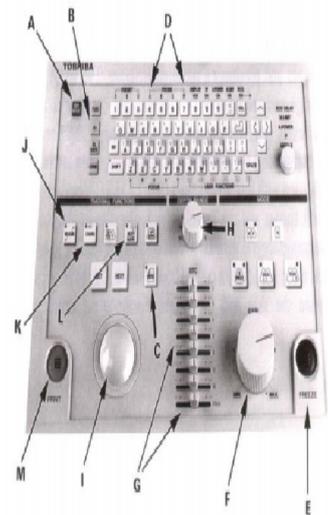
3D Ultrasound Machine
